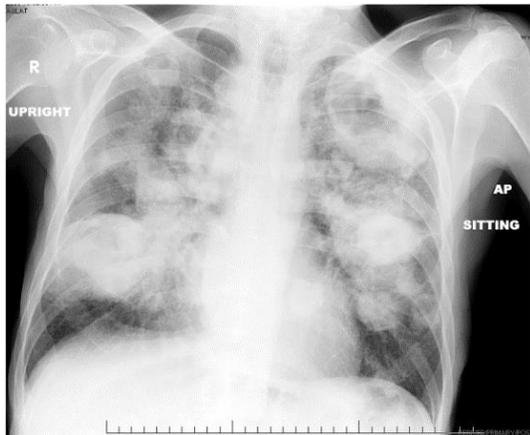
Chest x-ray shows cavitating lung lesions.
